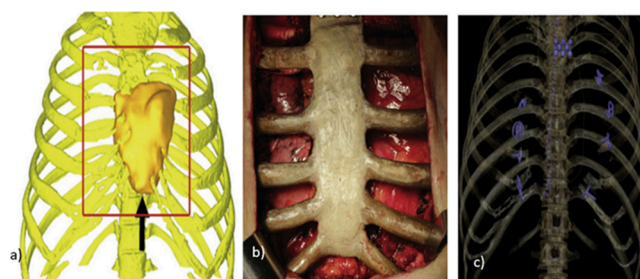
a) 3-D image for the reconstruction of the chest wall affected with a sternum tumor, b) AM fabricated PEEK implant fixed on the patient, and c) image of the chest CT after implantation. Adapted with permission from ref 121. Copyright 2019, Elsevier.
